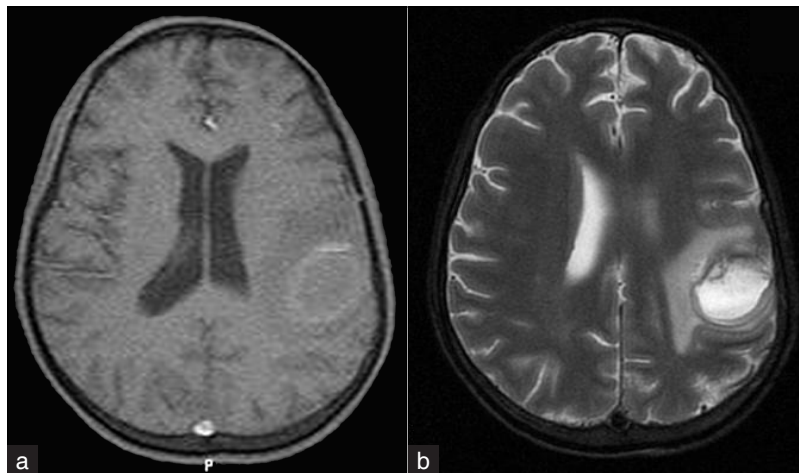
MRI brain axial section showing hypointense signal intensity alteration on T1WI (a) and hyperintense on T2 FLAIR (b) in left parietal region, suggestive of acute infarct. There is also perilesional edema
